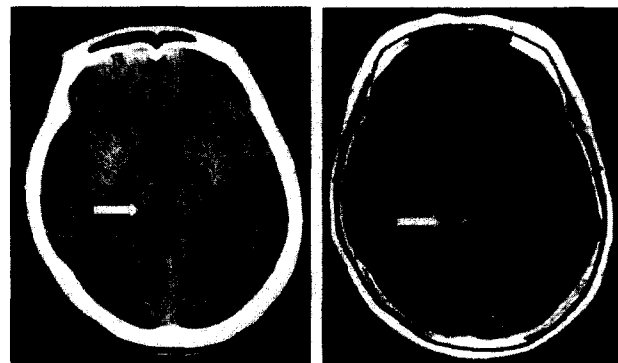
CT and MR image at the level of cistern of velum interpositum. The lesion(white arrow) showed fat density lesion on CT(a) and high signal intensity on T1-weighted MR imaging(b).
